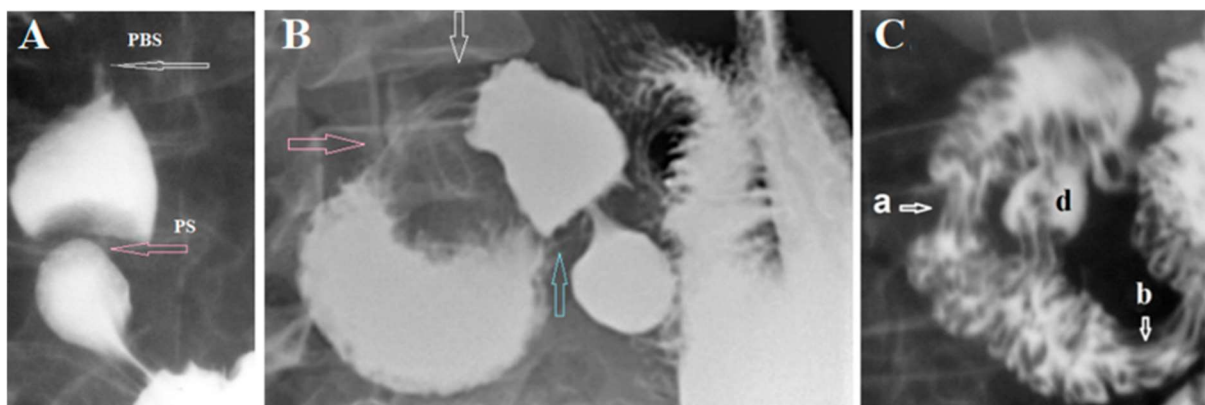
X-ray demonstration of the duodenal sphincters. (A). During antral contraction, the duodenal bulb fills to the limit, after which the pyloric sphincter (PS) contracts, stopping the flow of barium from the stomach into the bulb. Then, during the peristaltic contraction of the bulb between the PS and PBS, the pressure rises, which causes the PBS to relax, and the bolus penetrates the 2nd part of the duodenum. (B) In elderly patient with duodenal dyskinesia the white arrow shows PBS location. An expansion of the duodenum is determined between the Kapanji's sphincter (pink arrow) and the Ochsner's sphincter (blue arrow). (C) The duodenum was emptied, but the barium remained in deep folds because the barium-filled bowel was very wide. Two zones of contraction with longitudinal folds are visible: (a) the Kapanji's sphincter, and (b) the Ochsner's sphincter. The juxtapapillary diverticulum (d) is located between them.
